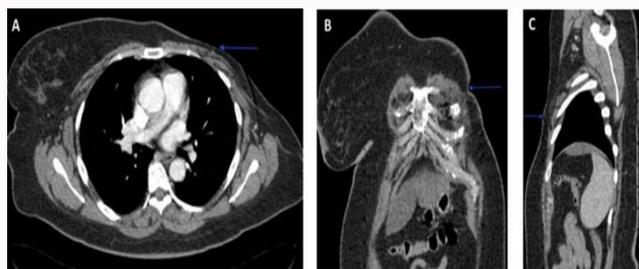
Selected images of a chest CT after IV contrast in the arterial phase and in the soft tissue window. A). Axial view (B). Coronal view (C). Sagittal view showing observed postsurgical changes (left mastectomy) without recurrent/residual masses (blue arrow).
